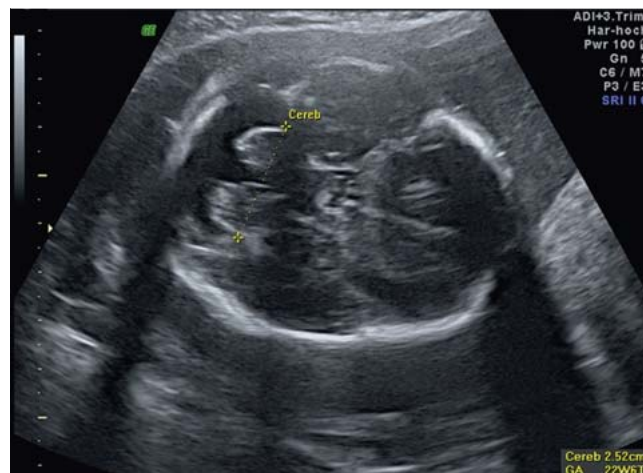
Fetal ultrasound imaging at 25 weeks of gestation shows hypoplasia of the cerebellar vermis with an enlarged cisterna magna.
